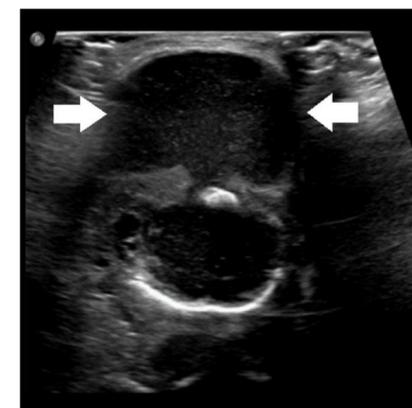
Midline ultrasound neck transverse view of neck mass (between arrows).
